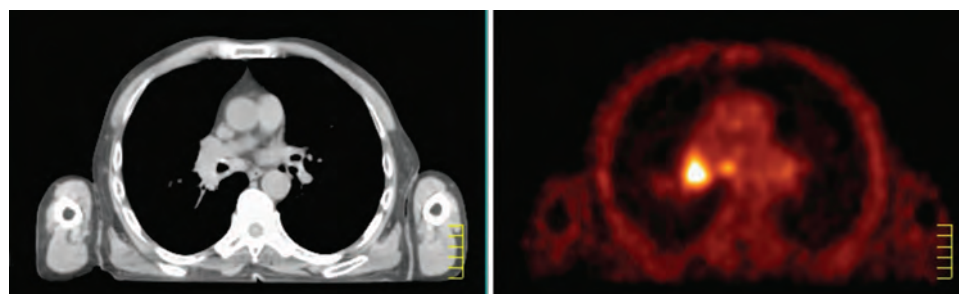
Transverse CT (left) and FDG-PET (right) slices showing tumor in the left hilus with a lymph node in region VII.
